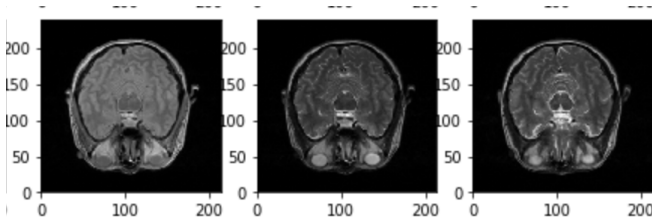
Inset of section of MRI with slices containing substantia nigra.
